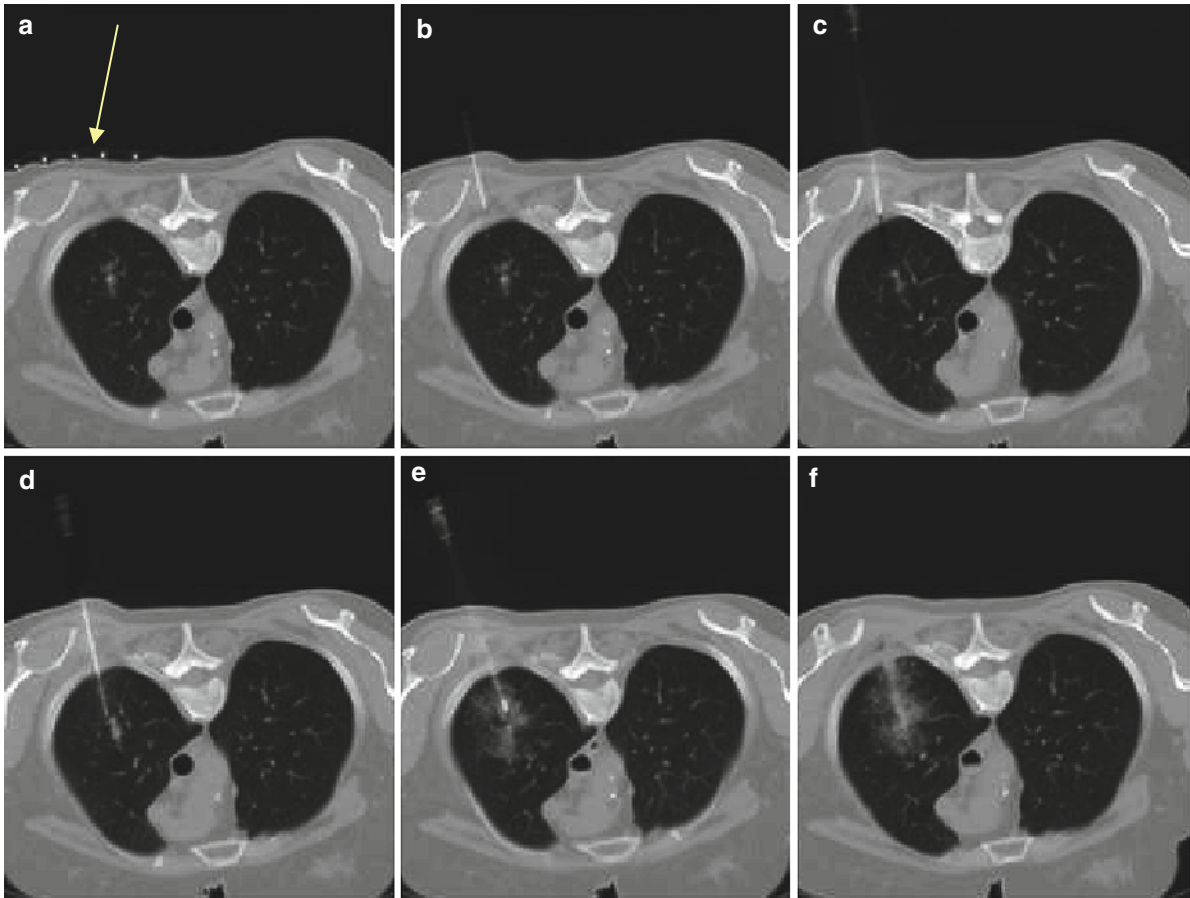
CT-guided lung biopsy in a patient with chronic lymphoid leukemia who developed small lung nodules. The procedure started with a short CT acquisition used to localize the lesion and to plan the needle trajectory. Radioopaque markers were placed on the skin to indicate the entry site (*arrow* on (a)).
